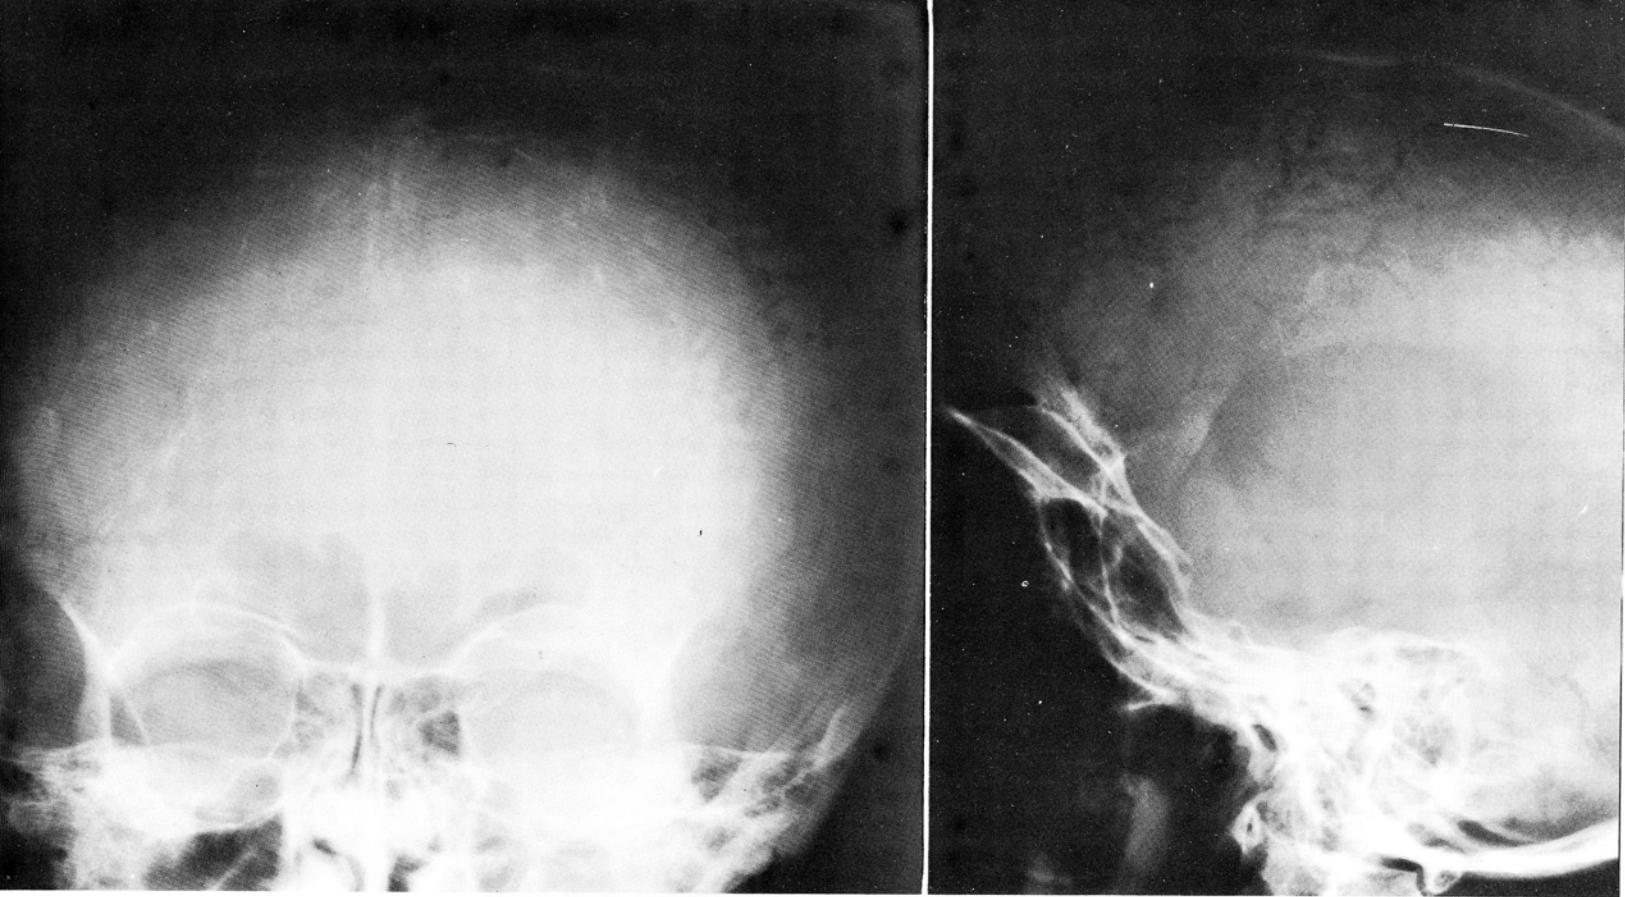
Frontal roentgenogram showing marked dilatation of the skull. Streaks of calcium near the surface of the brain, bilaterally, are not well demonstrated in the photographic reproduction.
